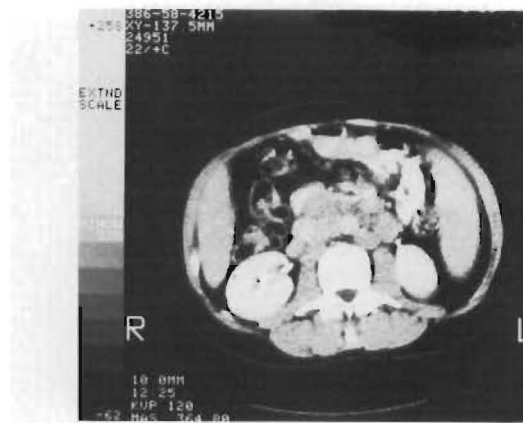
CT scan of the abdomen demonstrating periaortic enlarged nodes as part of the generalized lymphadenopathy of this patient's presentation.
